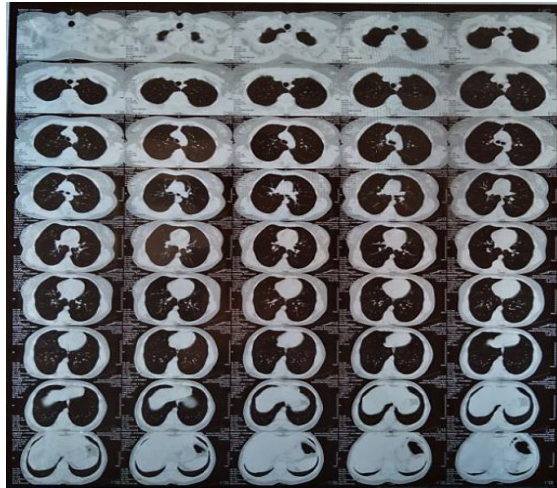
A: pure tone audiometry results. B: tympanometry results with type *An* in both ears. C: TEOAE results. D: HRCT scans of the lungs. Audiology test results of both ears were within normal limits. There was no sign of lung involvement in the HRCT scans of the lungs despite clinical picture and PCR positive to Covid19.
